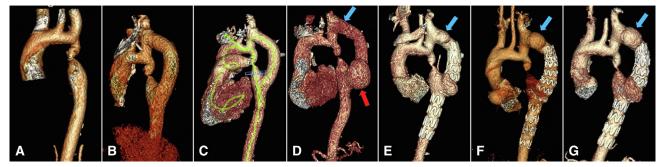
In 2013, an adult patient with MAS with a supravisceral lesion (A) was admitted and received LSA-DTA bypass. Postoperative 1-year (B) and 5-year (C) follow-up CTA showed satisfactory outcomes, whereas pseudoaneurysms at the proximal (*blue arrow*) and distal anastomosis (*red arrow*) were found in the postoperative 93-month CTA (D). The patient received reintervention of covered-stent implantation to isolate the distal pseudoaneurysm. In 3 months (E), 15 months (F), and 27 months (G) after reintervention, distal pseudoaneurysm remained stable though type II endoleak from lesioned aorta was observed, whereas the proximal pseudoaneurysm gradually increased (*blue arrow*). *MAS*, Midaortic syndrome; *LSA*, left subclavian artery; *DTA*, descending thoracic artery; *CTA*, computed tomography angiography.
